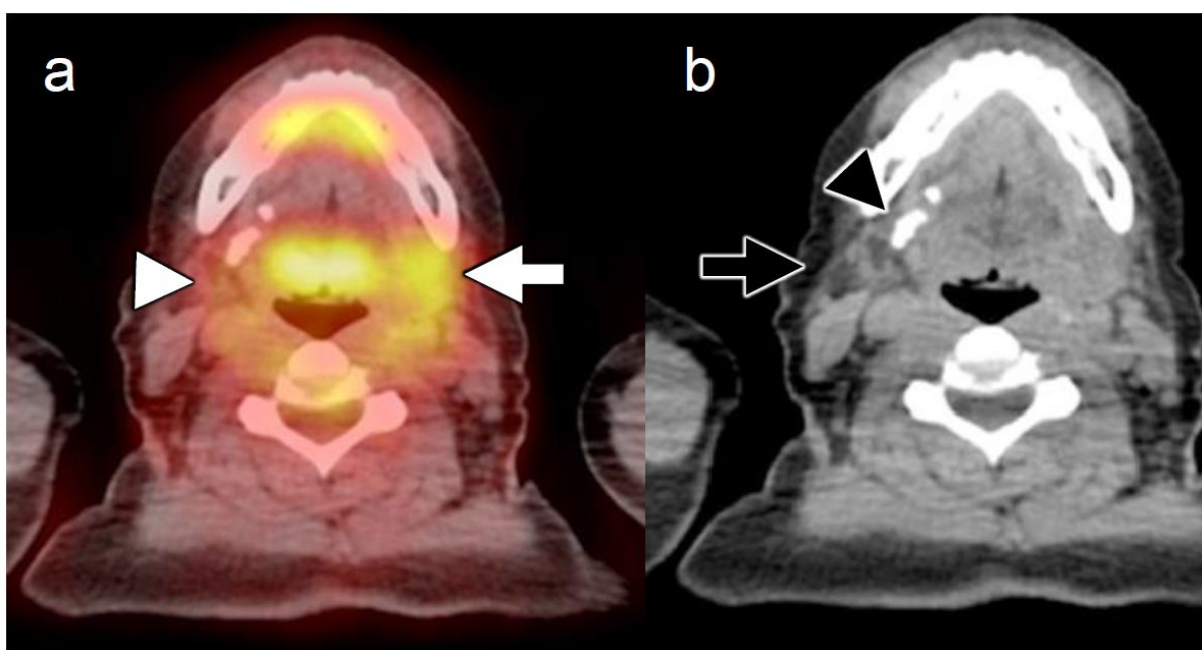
Asymmetric submandibular gland FDG uptake. Fused axial FDG-PET/CT (a) demonstrates asymmetric increased FDG uptake within the left submandibular gland (white arrow) relative to the right submandibular gland (white arrowhead). Axial NECT image in the same patient shows fatty atrophy of the right submandibular gland (black arrow) with associated large ductal calcifications (black arrowhead) from sialoliths that have chronically obstructed the submandibular duct. The left submandibular shows compensatory enlargement, but is otherwise normal in appearance.
